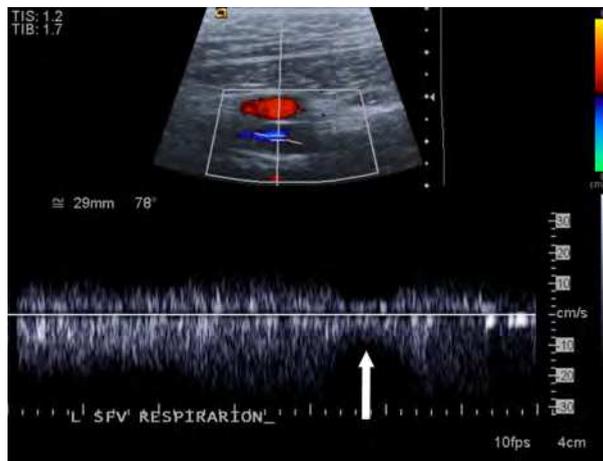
Duplex US. Normal phasic variation in Doppler waveform within the superficial femoral vein during deep respiration (*arrow*).
